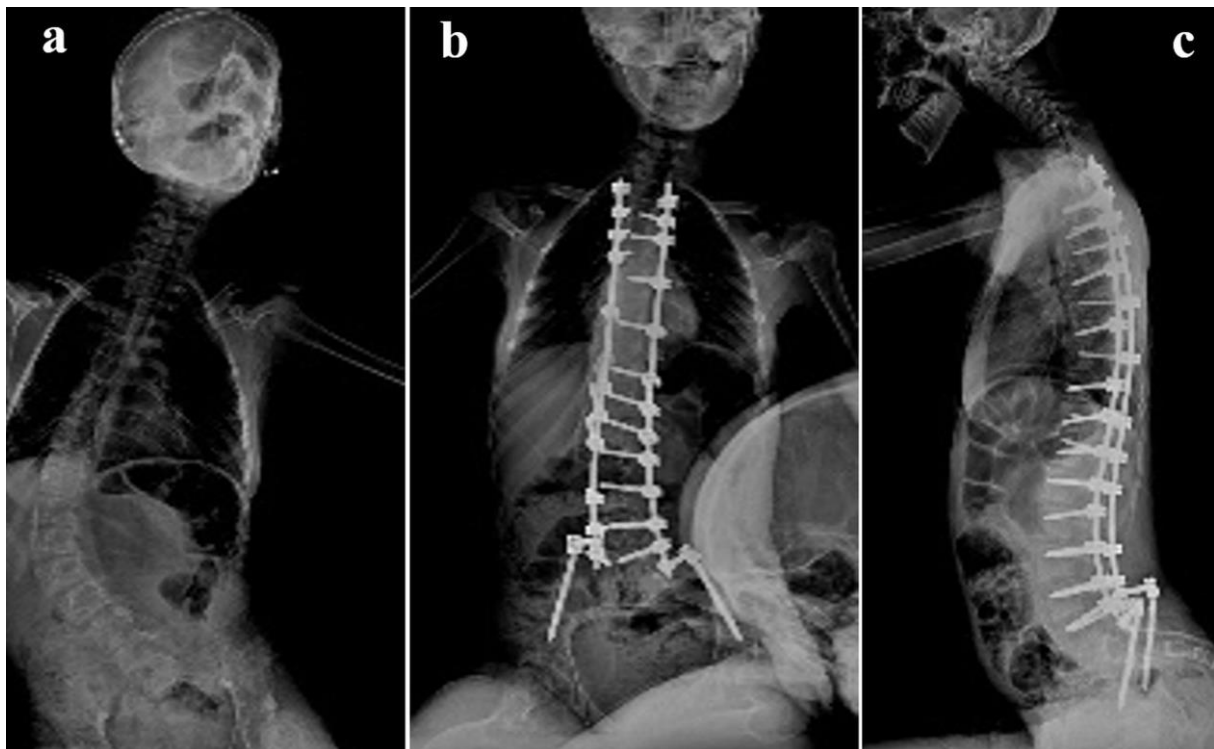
a, b, c. Pre- post operative X-rays.
